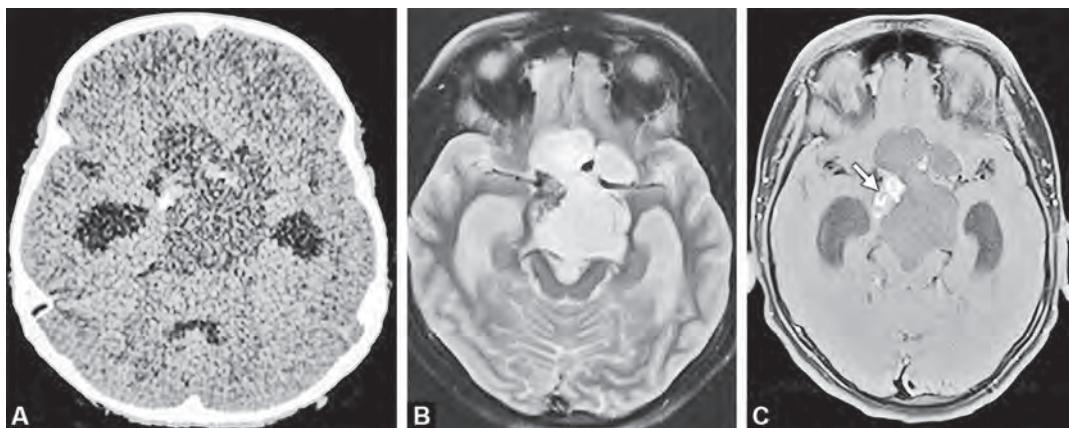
(A) Non-contrast axial CT image demonstrates a well-defined predominantly cystic suprasellar lesion with few calcific foci and associated hydrocephalus. (B) Axial T2W image demonstrates a well-defined multilobulated predominantly cystic lesion with peripheral hypointense solid component in the suprasellar region. (C) Post-contrast T1 FS image demonstrates enhancing solid component with subtle enhancement of the cyst wall along the left anterior aspect of the cyst (arrow)
